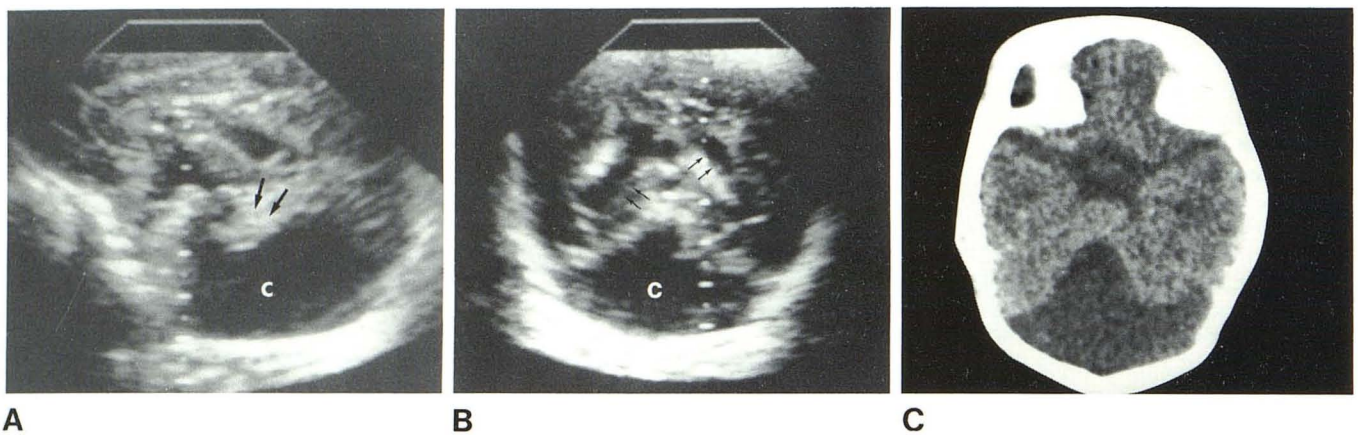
Case 2. A, Midline sagittal sonogram shows large fourth ventricle cyst (c). Vermis is displaced superiorly (arrows). B, Coronal sonogram. Large triangular cystic structure occupies most of posterior fossa (c). Dilated atria of lateral ventricle (arrows). C, CT scan shows cystic dilatation of fourth ventricle, with hypoplasia of cerebellar midline structures.
